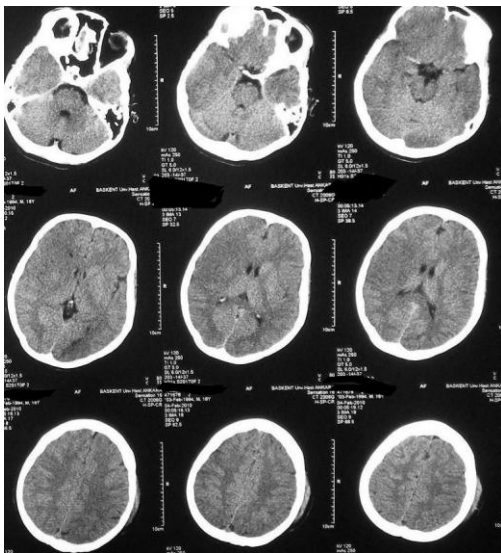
Axial CT shows a hyperdense MCA and subtle low density in the territory of the right MCA; the right Sylvian cistern is not observed.
